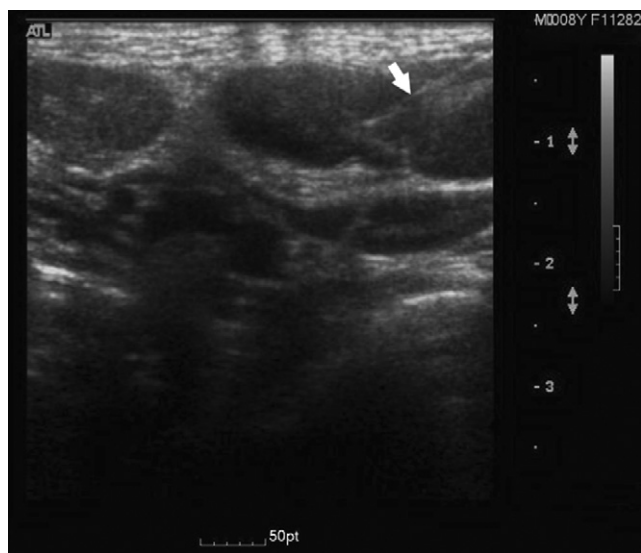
Fine needle (arrow) aspiration was done under the real-time guidance of ultrasound. Sonography showed matted, enlarged lymph nodes with hyperechoic rims.
